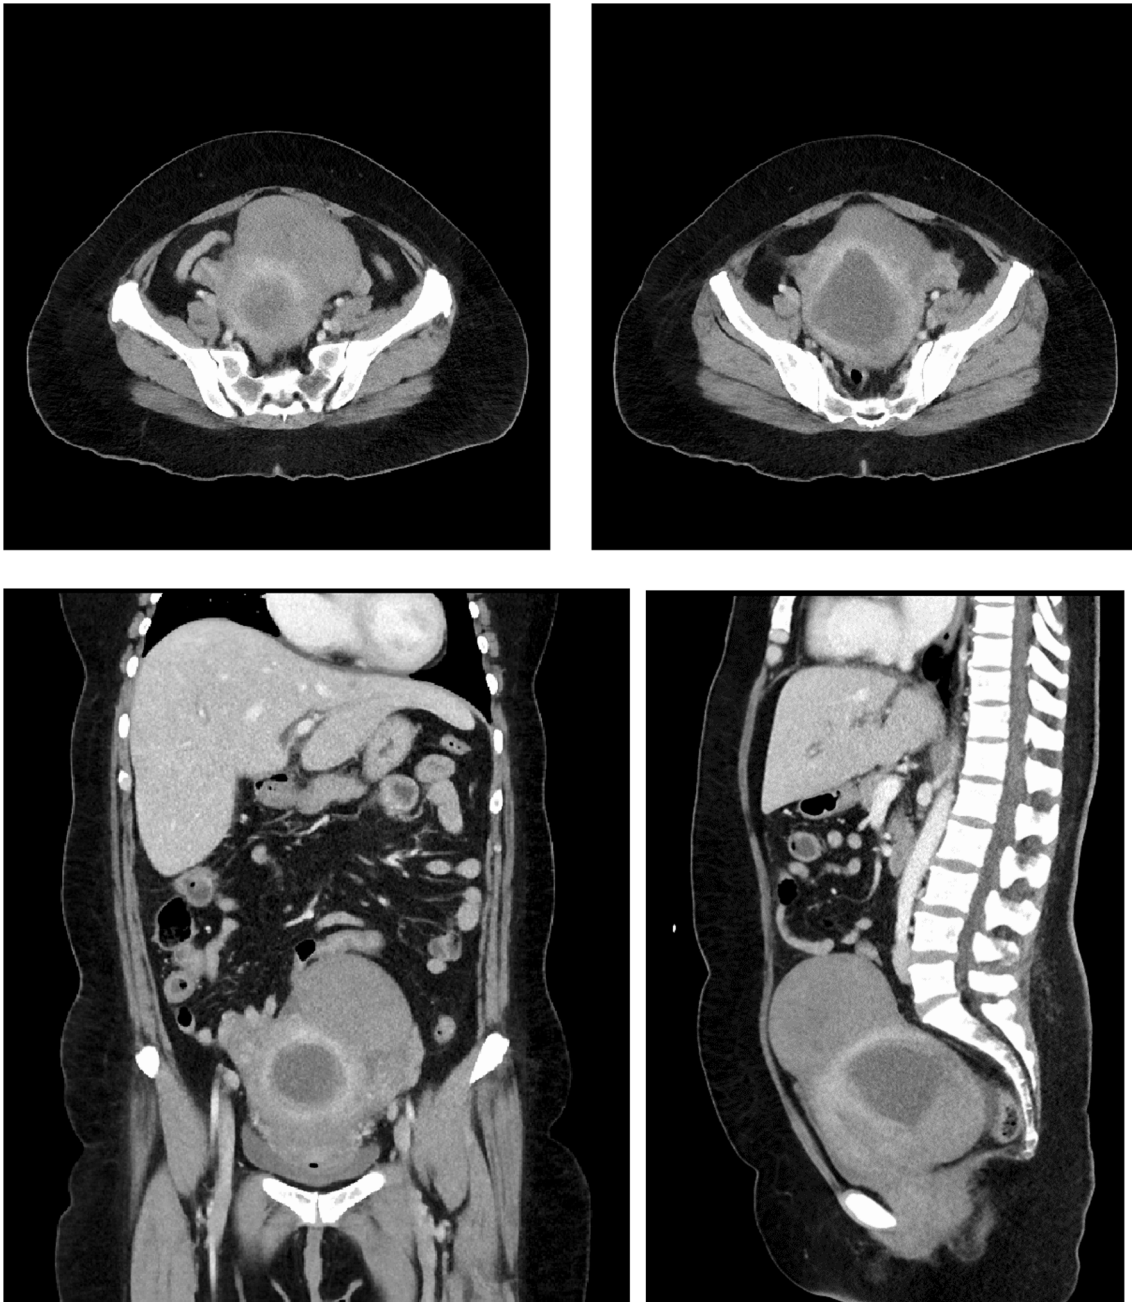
A-D. CT of the abdomen and pelvis demonstrating fibroid uterus with expanded endometrial cavity and 4 cm hyperdensity.
